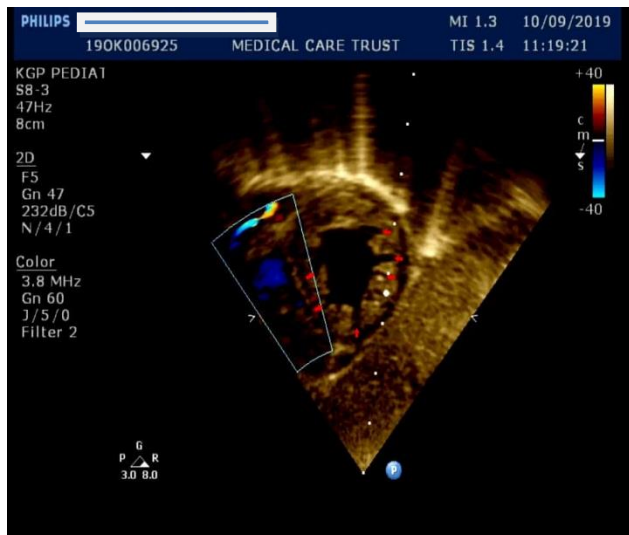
Still image of echocardiography reveals LV wall with multiple sinusoids accompanied by increased thickness both in end-systole and end-diastole.
